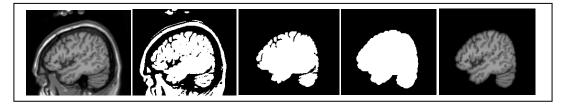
a- MRI filtered by NI-means; b- EM brain mask; c- Extraction of the largest component; d- dilatation; e- brain extraction.
